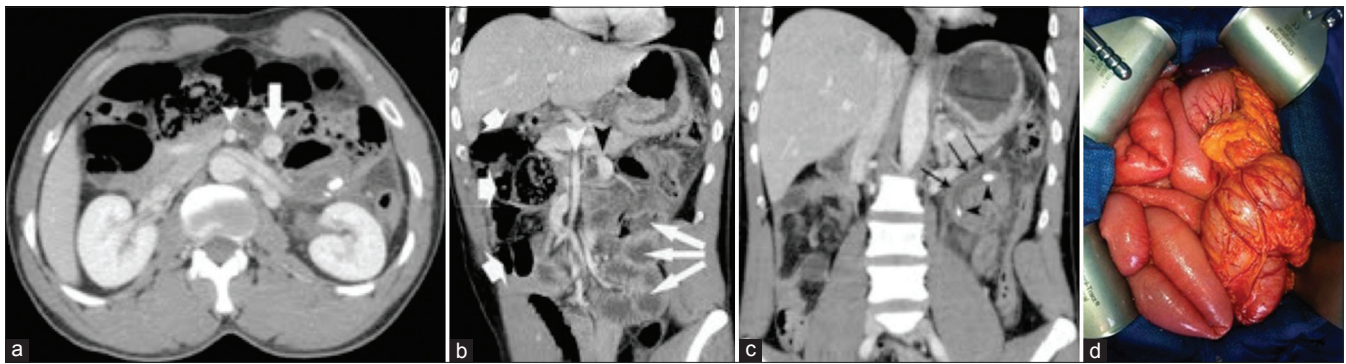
(a) Portal-venous phase computed tomography (CT) image. Superior mesenteric vein (arrow) is on the left side of the superior mesenteric artery (arrowhead); (b) Coronal multiplanar reformation (MPR) from portal-venous phase CT demonstrates a midgut malrotation. Superior mesenteric vein (black arrowhead) is on the left side of the superior mesenteric artery (white arrowhead). The entire small bowel (thin arrows) is in the left half of the abdomen and colon (thick arrows) is in the right half; (c) Coronal MPR from portal-venous phase CT demonstrates a acute upper left side appendicitis (arrows) with two stercoliths (arrowheads) and (d) Operative view with the entire small bowel in the right half of the abdomen and colon in the left half
